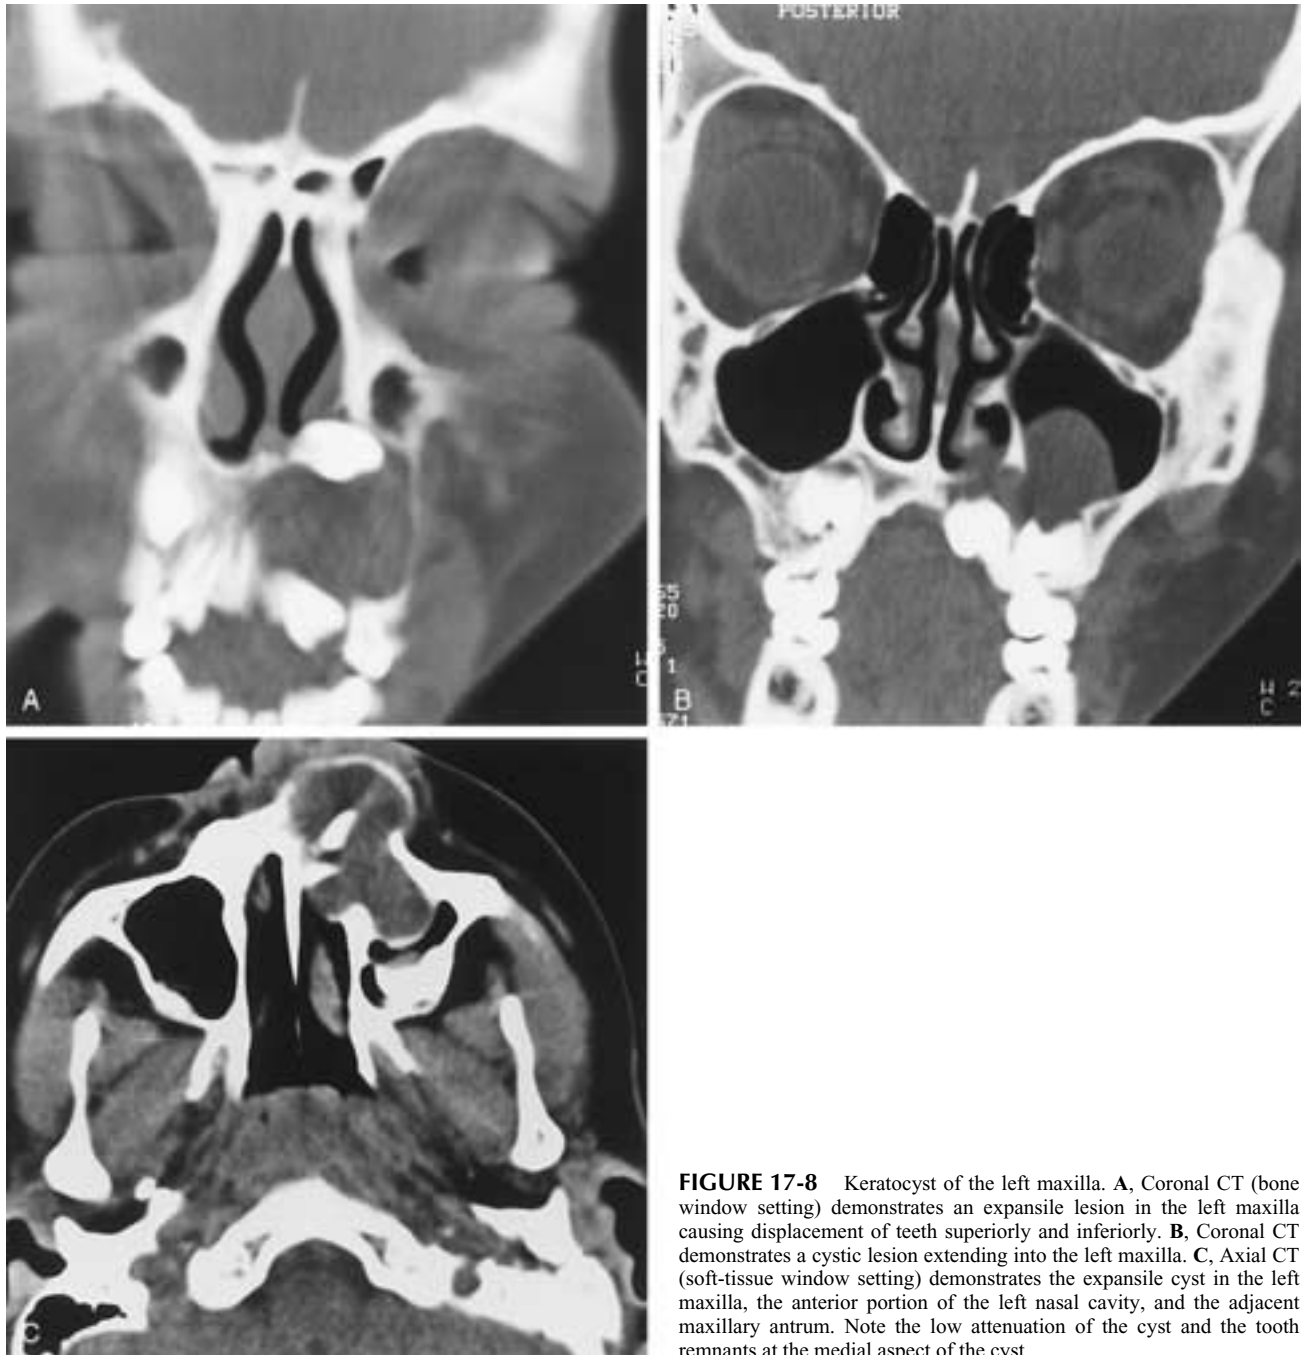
Keratocyst of the left maxilla. A, Coronal CT (bone window setting) demonstrates an expansile lesion in the left maxilla causing displacement of teeth superiorly and inferiorly. B, Coronal CT demonstrates a cystic lesion extending into the left maxilla. C, Axial CT (soft-tissue window setting) demonstrates the expansile cyst in the left maxilla, the anterior portion of the left nasal cavity, and the adjacent maxillary antrum. Note the low attenuation of the cyst and the tooth remnants at the medial aspect of the cyst.
